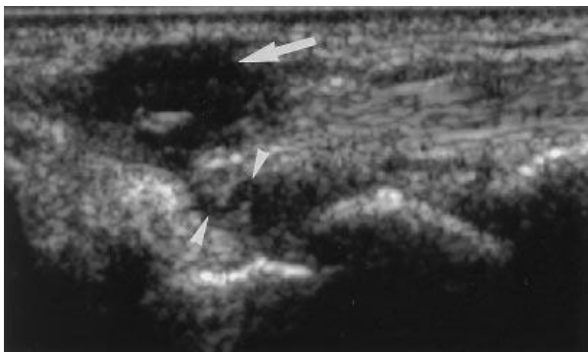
"A 27-year-old woman with dorsal ganglion of the wrist. Ultrasound, sagittal plane: The lesion (arrow) appears as a hypoechoic mass located in the subcutaneous tissue. A tortuous pedicle connecting the ganglion to the joint is evident (arrows)"^[11]
